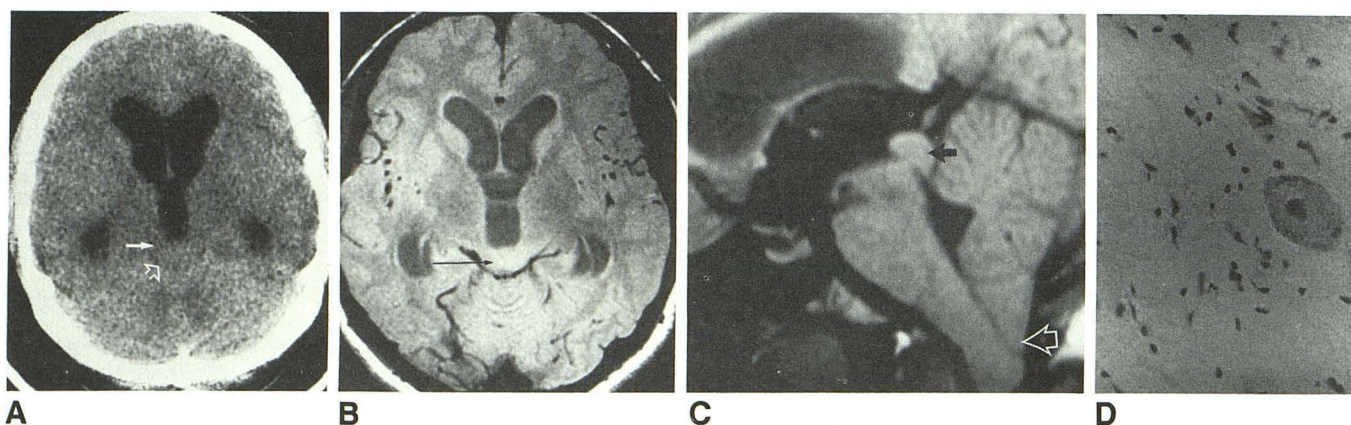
A, Plain CT scan performed before ventricular shunting shows lesion at quadrigenital plate (closed arrow) compressing quadrigenital plate cistern (open arrow) and causing hydrocephalus.
